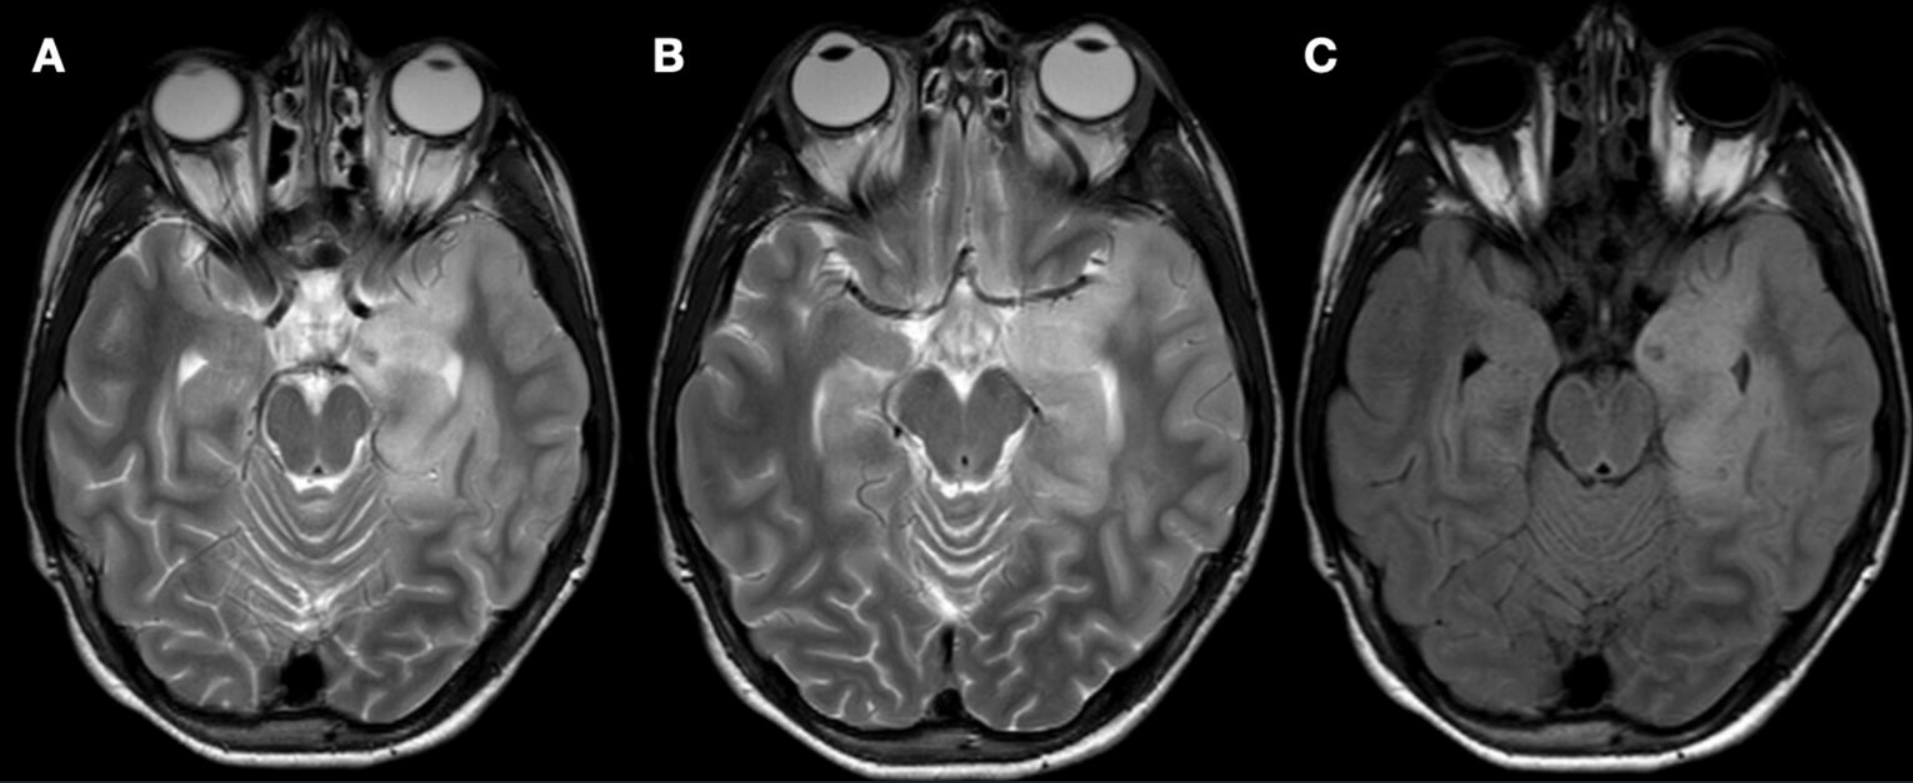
Axial T2 (Images A and B) and FLAIR (Image C) cross sections with hyperintense signal involving the left medial and anterior temporal lobes. A small punctate microhemorrhage is seen in the left medial temporal lobe.
